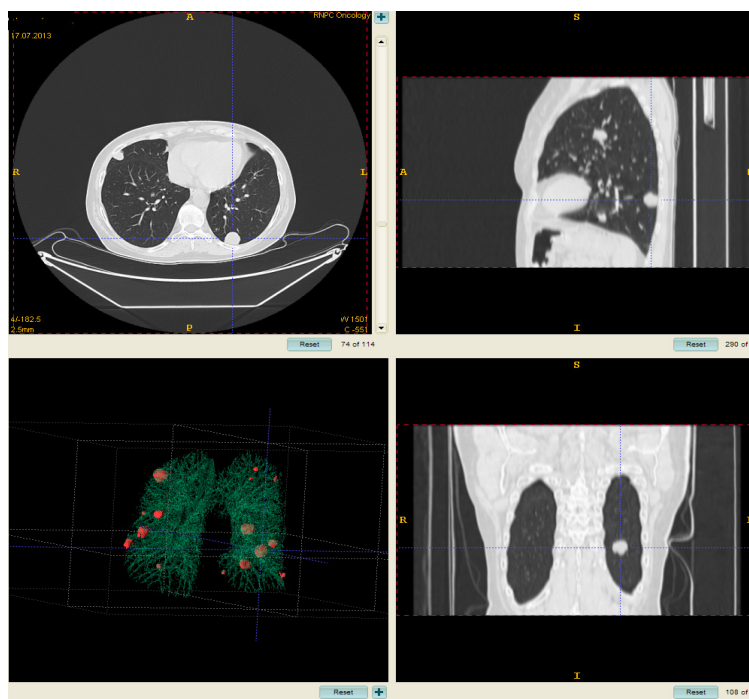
Example of multiple nodule detection on a CT scan using the algorithm proposed
